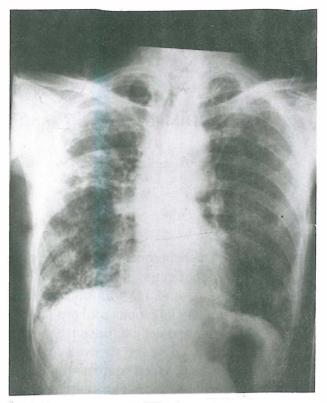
Chest x-ray film showing reticulofibrotic changes of both lung fields.
